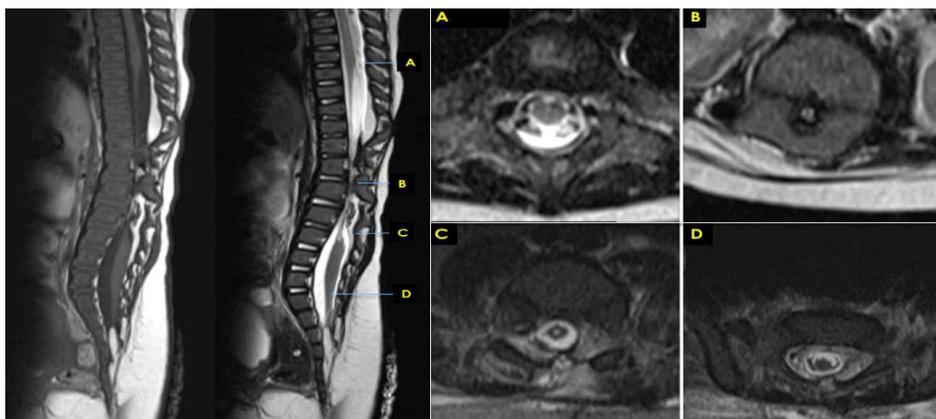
Pre-operative spinal MRI of a patient with junctional neural tube defect.
